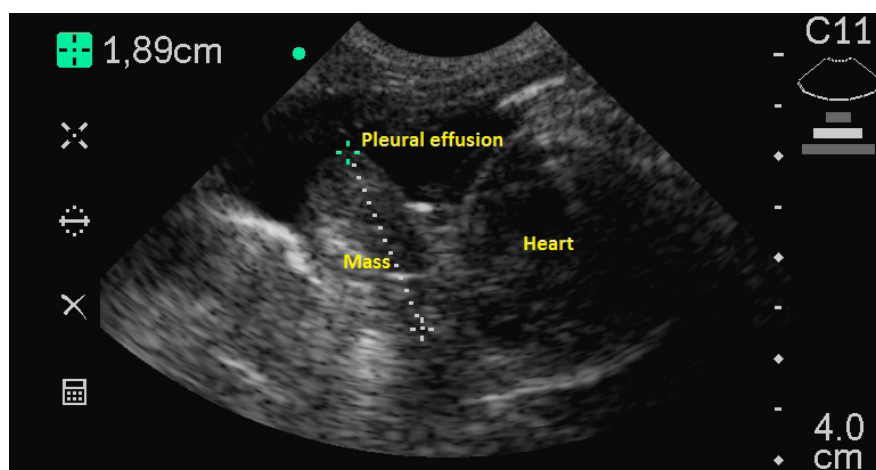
Echocardiographic image of the right parasternal short-axis showing a 1.89-cm mass located cranially to the heart. Pleural effusion can be seen dorsally to the mass and heart
